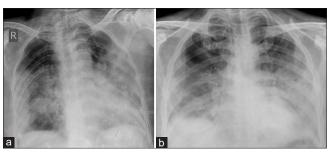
(a and b) Chest X-ray of patients showing bilateral diffuse infiltration
